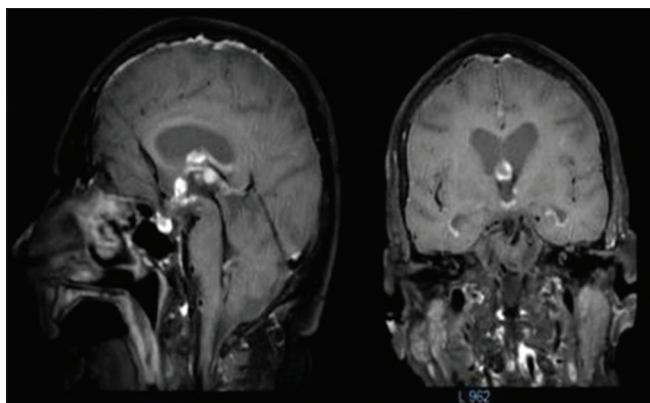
Magnetic resonance imaging of the brain showed multiple solid lobulated enhancing masses of variable size involving the lateral and third ventricles and extending into the periventricular white matter; these lesions appeared mildly hypointense on T2-weighted images and did not show any diffusion restriction of diffusion-weighted images. No other parenchymal lesion was observed. Positron emission tomography-computed tomography did not show any extra-extracranial fluorodeoxyglucose avid lesion
